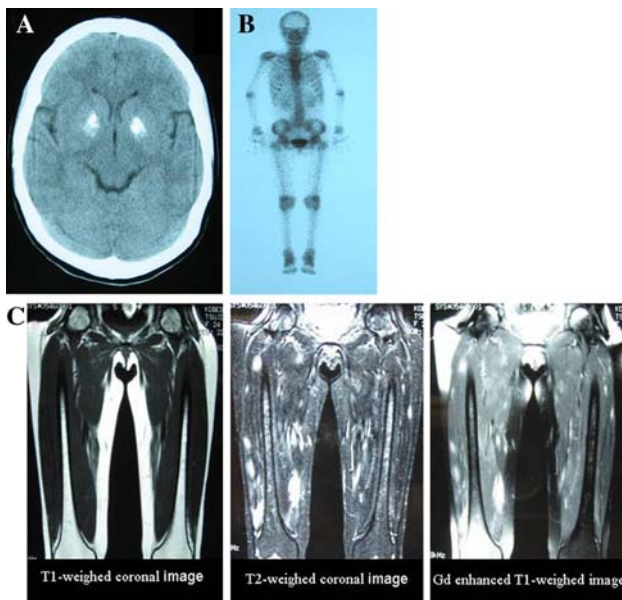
a A computed tomography scan of the brain showed calcification in basal ganglia. b Bone scan (^{99m}Tc -methylene diphosphonate) revealed increased uptake in bilateral shoulder, knee, elbow, wrist, and foot joints. c Magnetic resonance images of the distal thighs. *Left* T1-weighted image, *middle* T2-weighted image, and *right* gadolinium-enhanced T1-weighted image
